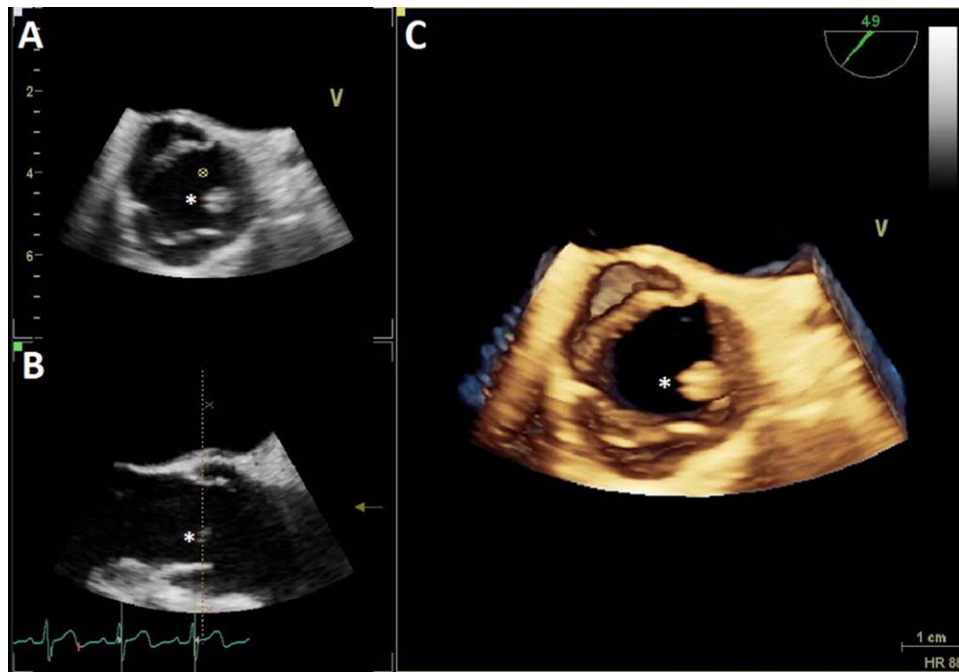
Transesophageal echocardiography of a papillary fibroelastoma (asterisks) of the left coronary leaflet of the aortic valve: (A) Atypical short axis view of 49°. (B) Long axis view showing the left ventricular outflow tract, the aortic valve, the fibroelastoma and the aortic bulb. (C) Three-dimensional reconstruction of the aortic valve.
